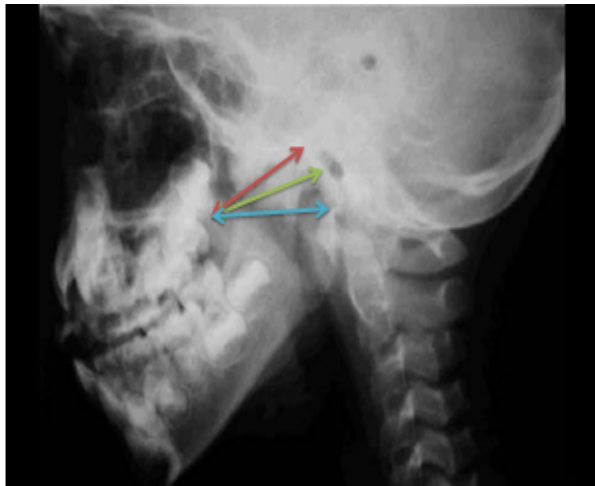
Showing the lines on lateral X-Ray of nasopharynx
